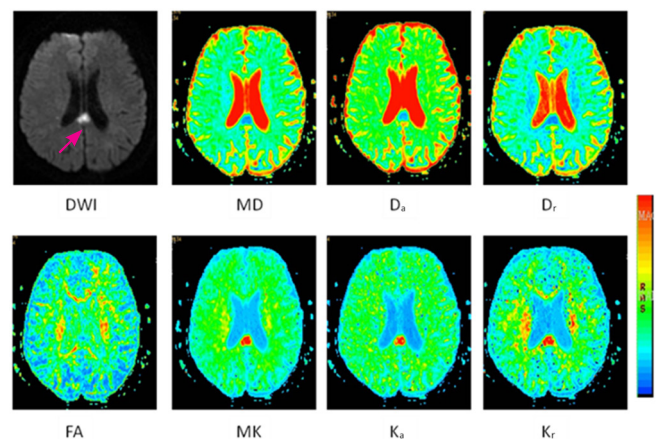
DKI-derived metric maps with a lesion (pink arrow) located in the corpus callosum from a 38-year-old female acute ischemic stroke patient (onset duration < 72 hours). The signal intensity change of the lesion was the same as the lesion in the periventricular white matter area in Figure 4. DWI: Diffusion weighted imaging; MD: mean diffusivity; D_a : axial diffusivity; D_r : radial diffusivity; FA: fractional anisotropy; MK: mean kurtosis; K_a : axial kurtosis; K_r : radial kurtosis; DKI: diffusion kurtosis imaging.
